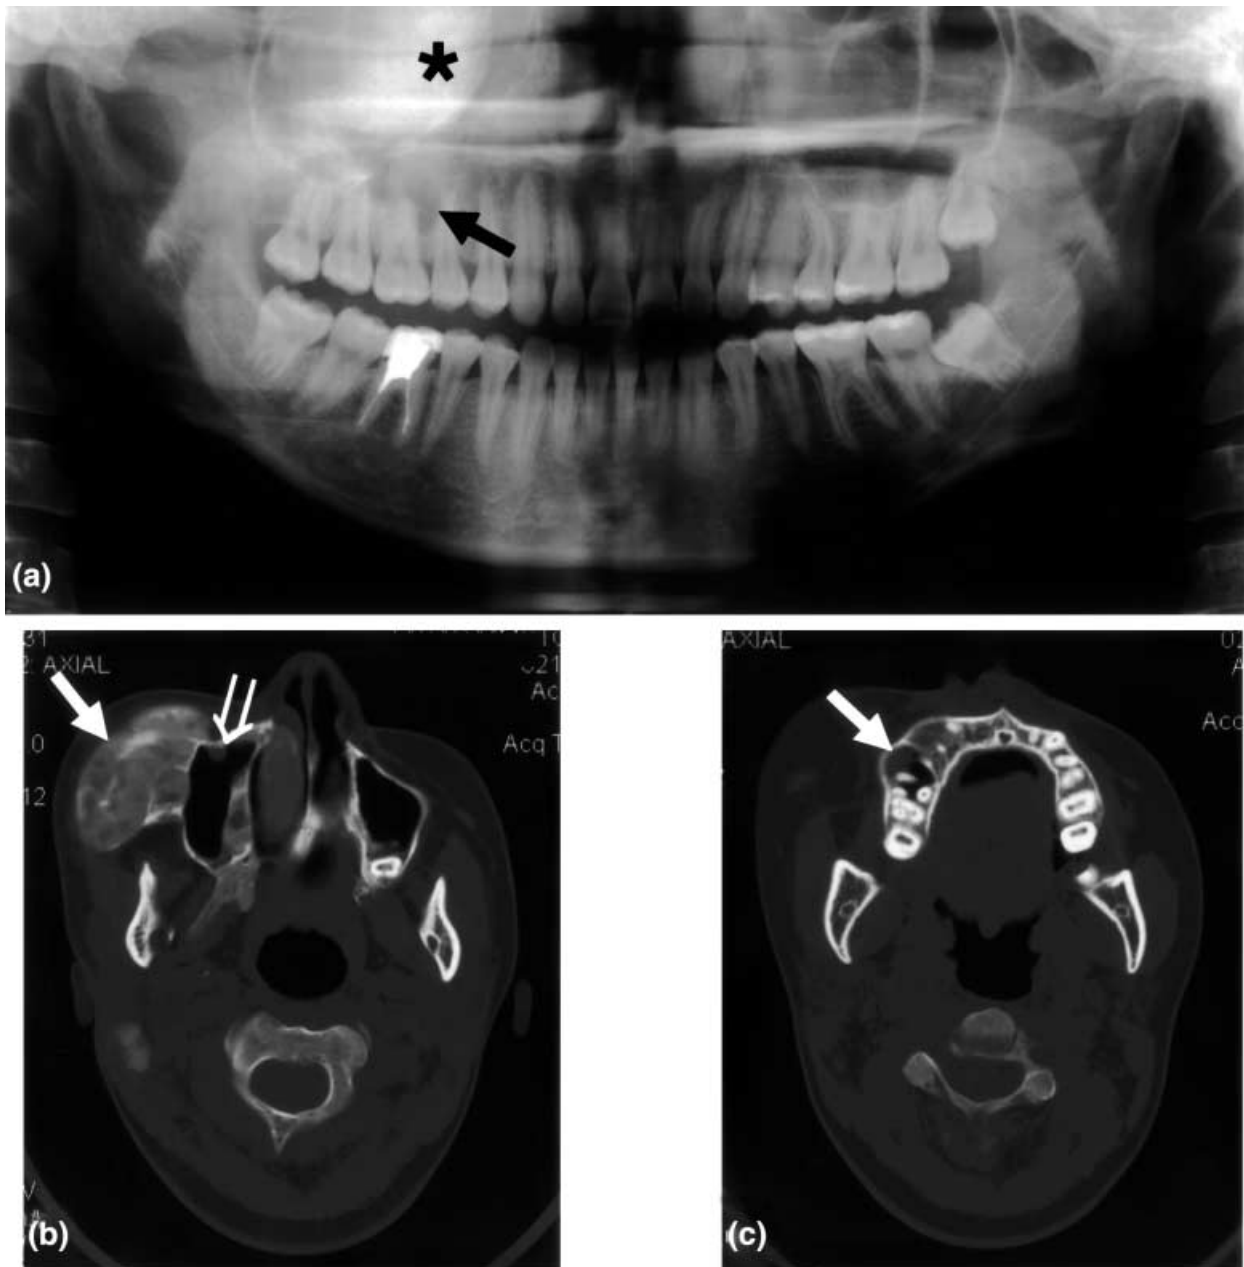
Ground glass pattern. Fibrous dysplasia of right maxilla in a 20-year-old female patient. Panoramic radiograph (a) shows ground glass appearance of right maxilla and opacification of maxillary sinus (star, a). Note the visible scalloping of sinus floor between roots of teeth nos 1–6 (solid black arrow). Computer tomographic views (bone windows) of same lesion at different levels show ground glass lateral expansion of maxilla (solid white arrow, b), a compressed but intact maxillary sinus (open white arrow, b) and extension of sinus into the alveolar region between roots of teeth nos 3 and 4 (solid white arrow, c)
